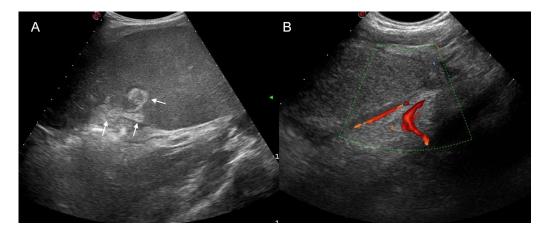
(A) Whirled and hyperechoic appearance of splenic vessels in the hilar region (arrows). (B) Nonhomogeneous spleen without vascular signals on color Doppler investigation.
